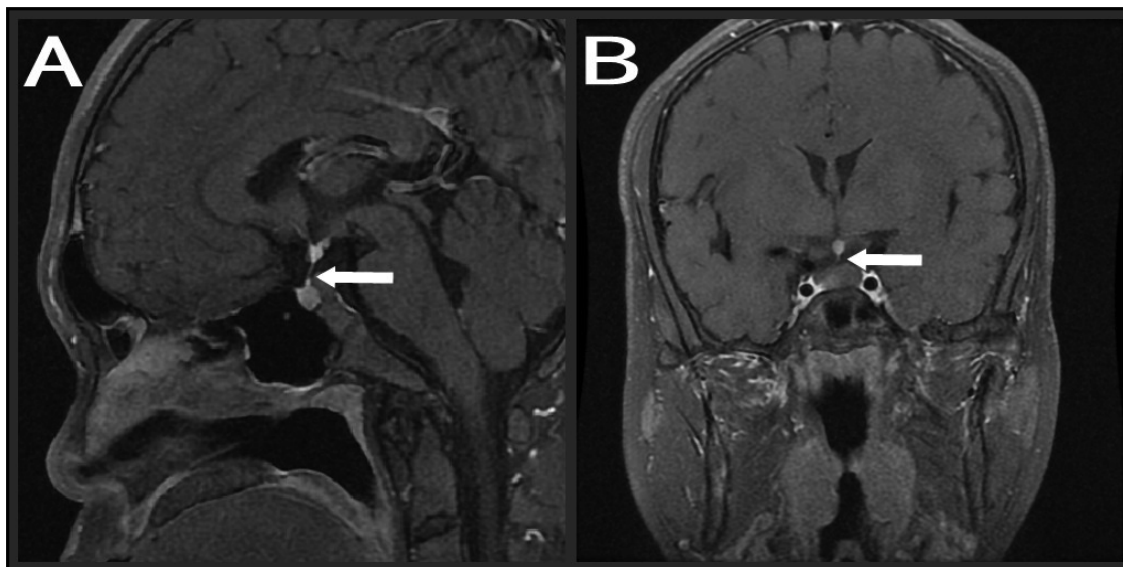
Pituitary MRI of case 2
